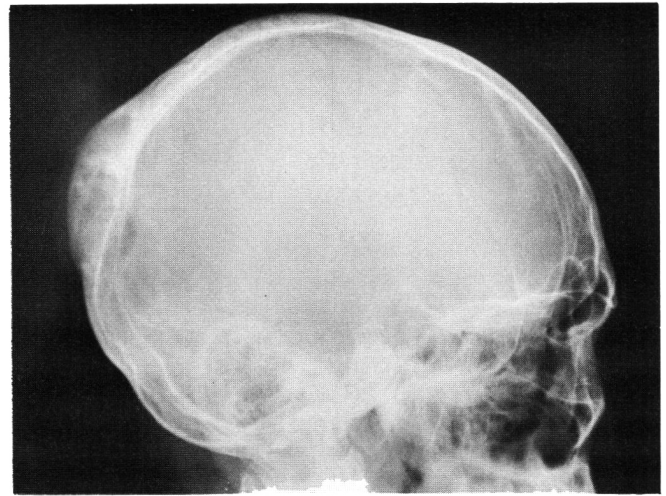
Radiograph of case 4 shows an expansile mass with a number of small cystic cavities. Most of the expansion is outward.
